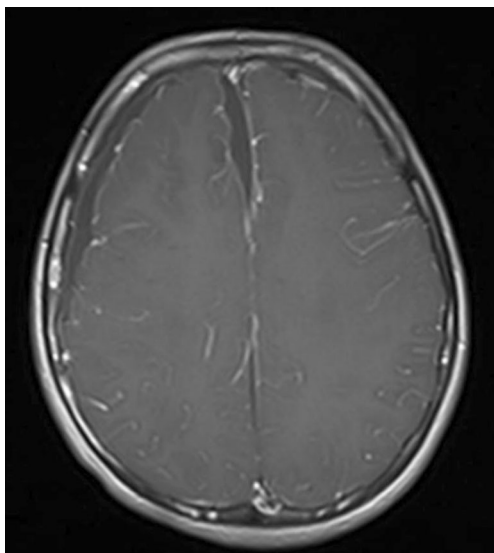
Axial T1-weighted MR image with gadolinium at admission showing a right frontal subdural and a parafalcine collection
